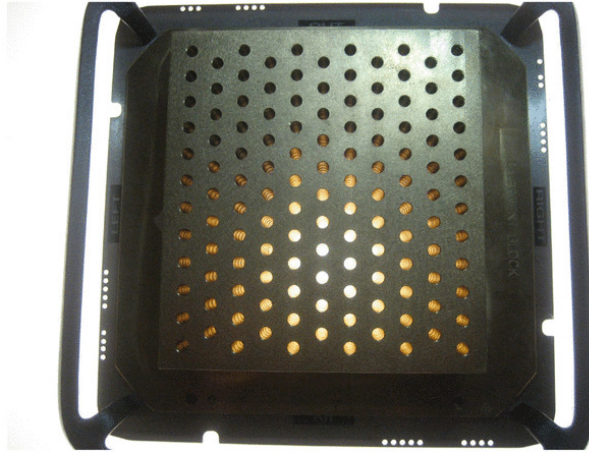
Grid collimator used with megavoltage x-ray beams. Taken from the work of Buckey et al. [Buckey 2010].
